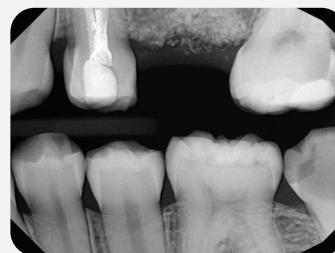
Pre operative radiograph showing decay on teeth 15, 18, and 19.
